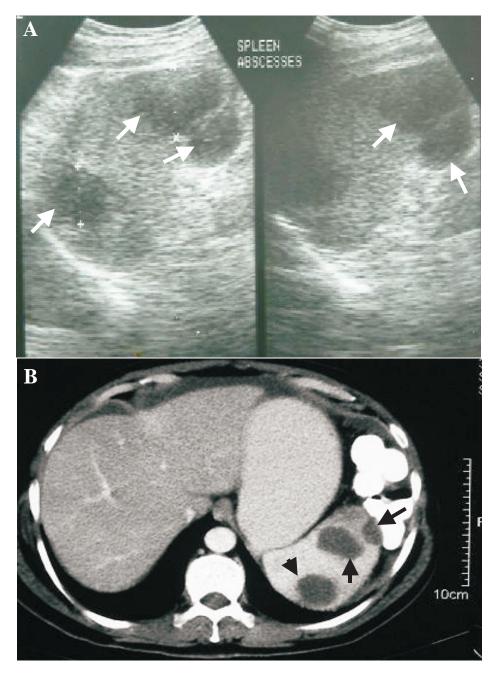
A, B. Multiple large hypoechoic lesions (arrows) seen on ultrasound (A); and confirmed by multiple large hypodense lesions seen within the spleen on CECT of the same patient (B).
